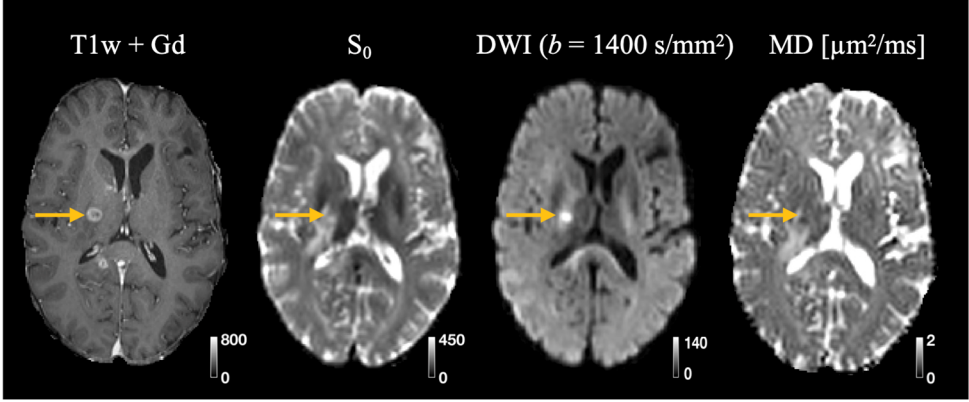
MRI in a patient with an astrocytoma of grade II. On the contrast-enhanced T1w image, an enhancing lesion can be seen (marked with a yellow arrow). On a map obtained without diffusion encoding (S_0), a hyperintense region can also be seen. However, on the DWI scan at $b = 1400 \text{ s/mm}^2$ a hyperintense lesion can be seen that is not visible on the S_0 map. The MD map shows a slight relative decrease of the MD in the corresponding region. Figure adapted from Paper III, published by Frontiers Media and licensed under CC BY 4.0.
